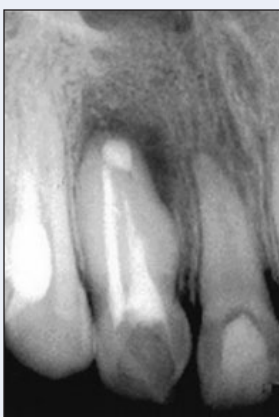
Immediate post-surgery radiograph.
